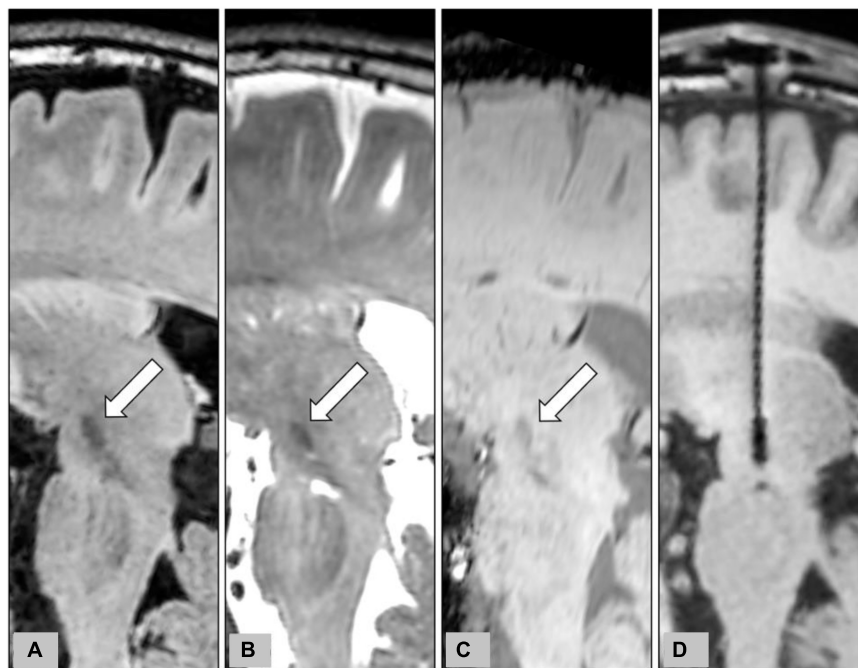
Representative case to show the delineation of STN on different MR pulse sequences for the planning of STN-DBS surgery. The planned trajectory for the right STN-DBS lead was demonstrated on the oblique sagittal reconstruction of pre-operative 3D FLAIR (A), T2WI (B), and SWI (C). The target structures, the STN, were indicated by white arrows on pre-operative images. The final position of the electrode was also shown on the oblique sagittal reconstruction of post-operative T1WI (D).
